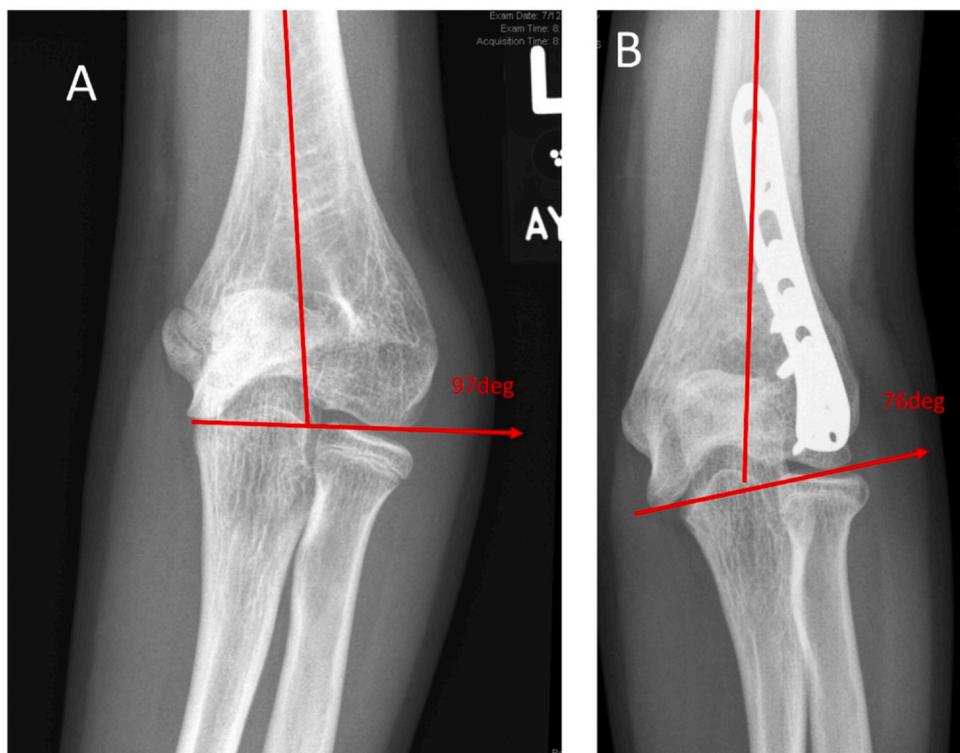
Radiographic measurement of distal humeral angle preoperatively (A) and postcorrection (B).
